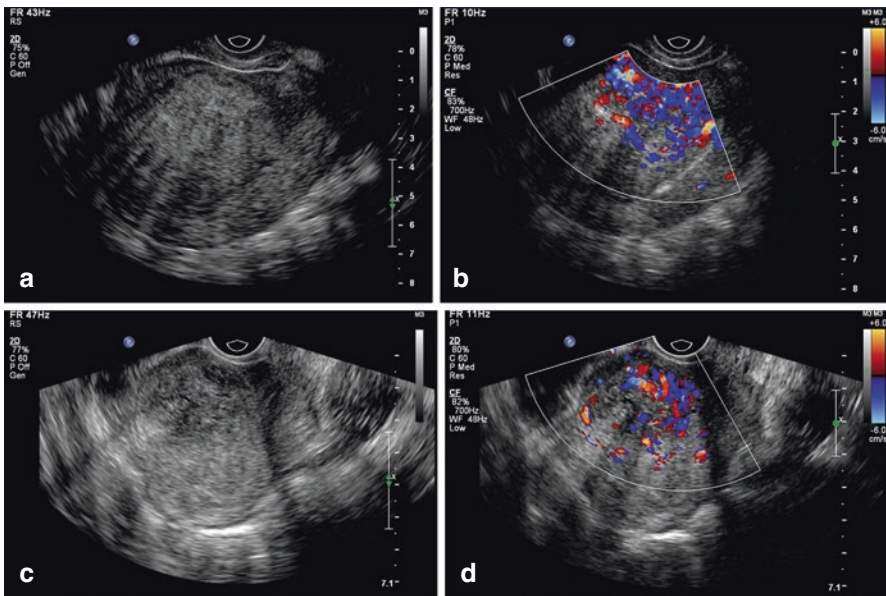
a and b TVUS images of diffuse adenomyosis of the anterior wall of the uterus, the uterus is anteverted. (a) is a grey-scale ultrasound image showing a marked thickening of the anterior wall of the uterus, significantly uneven echoes, and fan-shaped sound shadows. (b) is a color doppler flow imaging (CDFI). The CDFI image shows abundant myometrial blood vessels with increased blood flow signals. (c and d) TVUS images of focal adenomyosis, the uterine position is also anterior in this case. (c) is a grey-scale ultrasound image showing focal lesions with uneven echoes visible in the anterior wall uterine myometrium, and the border is unclear. (d) is a CDFI image showing an increase in blood flow signals within the lesion
